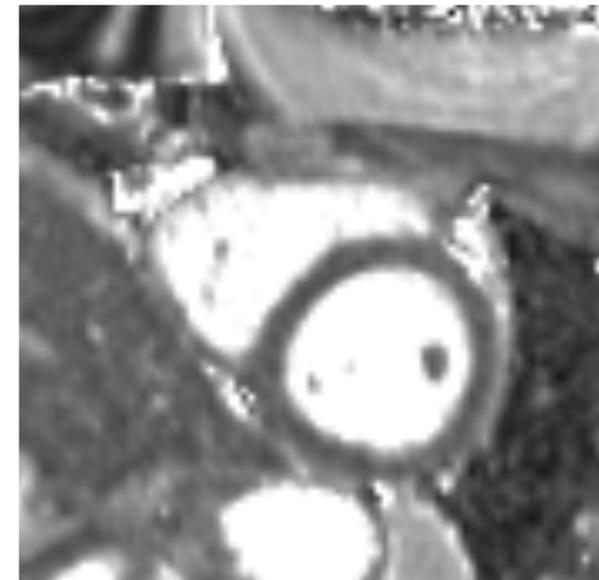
Cardiac MRI with evidence of regional myocardial edema
